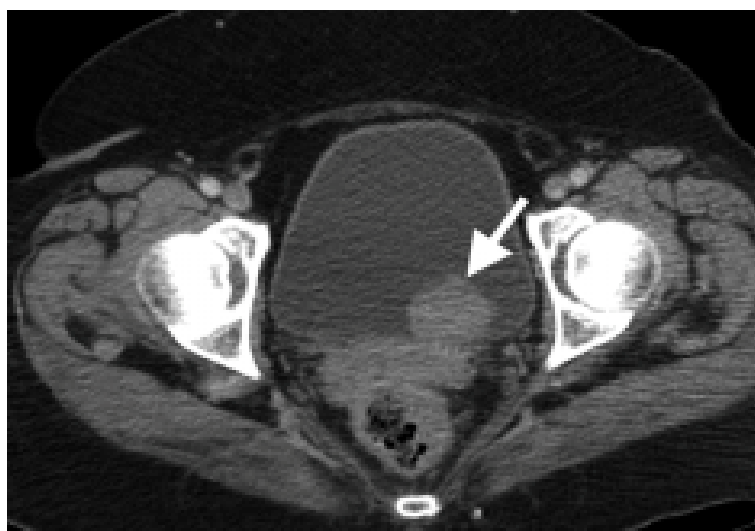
Bladder Tumour In CT Scan
